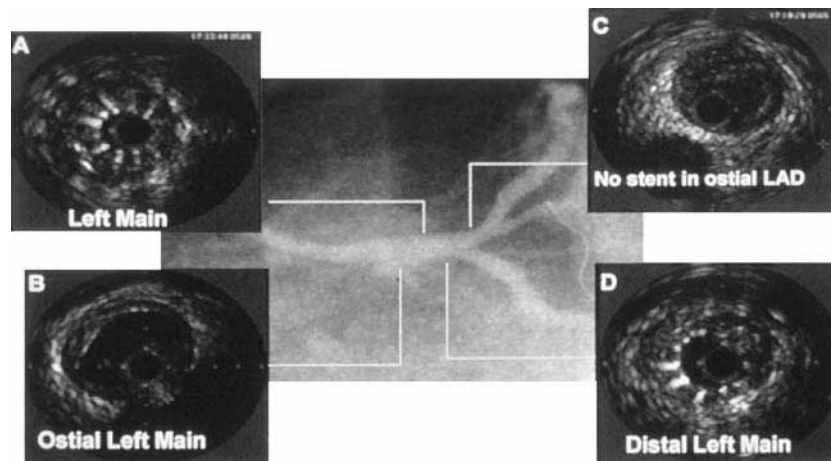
An acceptable angiographic result was obtained. IVUS was then performed to confirm that the stent had been placed precisely at the ostium without obstructing the circumflex artery. The ultrasound images provided a surprise. The reflections from the metallic stent struts were seen in the mid (A) and distal left main artery (D) and no stent struts were seen at the ostium of the LAD (C). In addition, the stent struts were only mildly expanded in the distal left main and were not expanded at all in the mid left main. This indicates that the stent had slipped off of the balloon and migrated to the more proximal left main artery.
